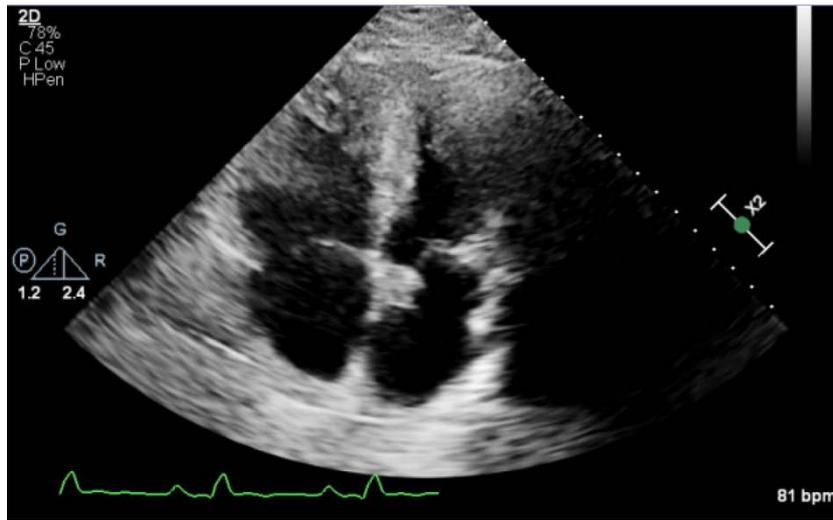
Transthoracic echocardiography at the day of PCI revealed EF of 30-35%, severe hypokinesia of the anterior, mid-distal, anteroseptal, and apical wall(s), and systolic and diastolic flattening of ventricular septum which may indicate right ventricular (RV) volume and/ pressure overload. RV was moderately to markedly dilated and atrial septum showed prominent Doppler flow noted at the mid-upper septum suggestive of an atrial septal defect
